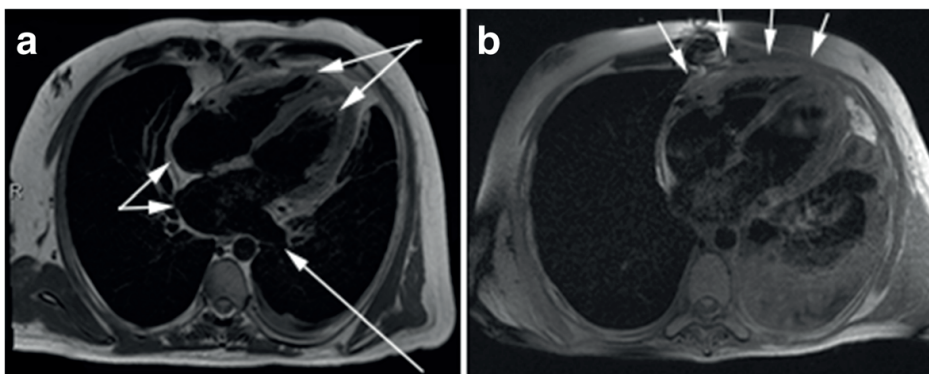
T2 Fat Sat Horizontal long-axis fat-suppressed T-2 weighted images. Preoperative cardiac MRI (a) reveals hepatic vein dilatation, atrial enlargement and ventricular narrowing (arrows). Post- operative cardiac MRI (b) fails to demonstrate any appreciable pericardial effusion or inflammation, with no increased T2 signal that would suggest edema (*arrows*).
